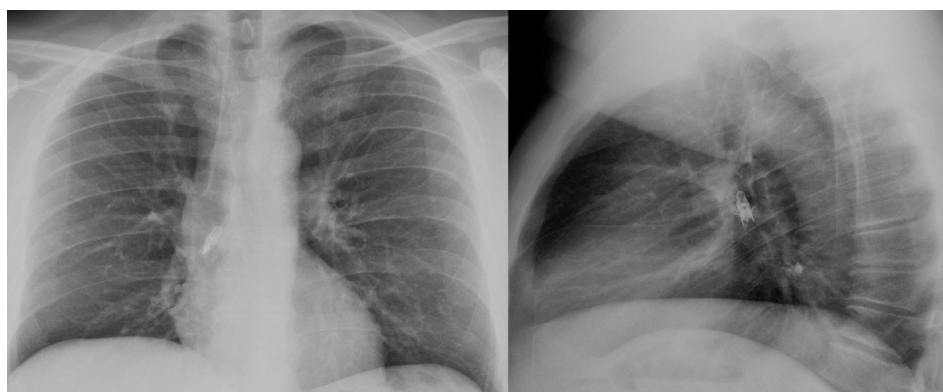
Posteroanterior and lateral chest radiograph, showing the foreign body (LED light bulb) lodged in the right main bronchus.
